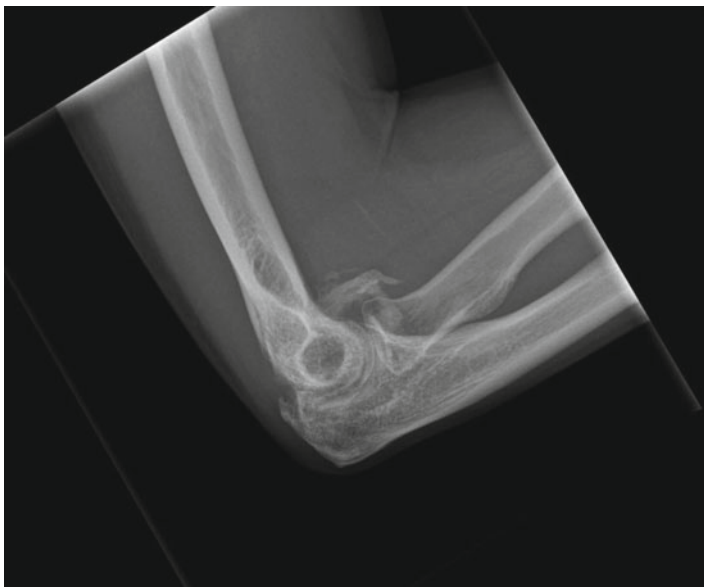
Radiograph showing heterotopic ossification of the anterior capsule of the elbow joint
